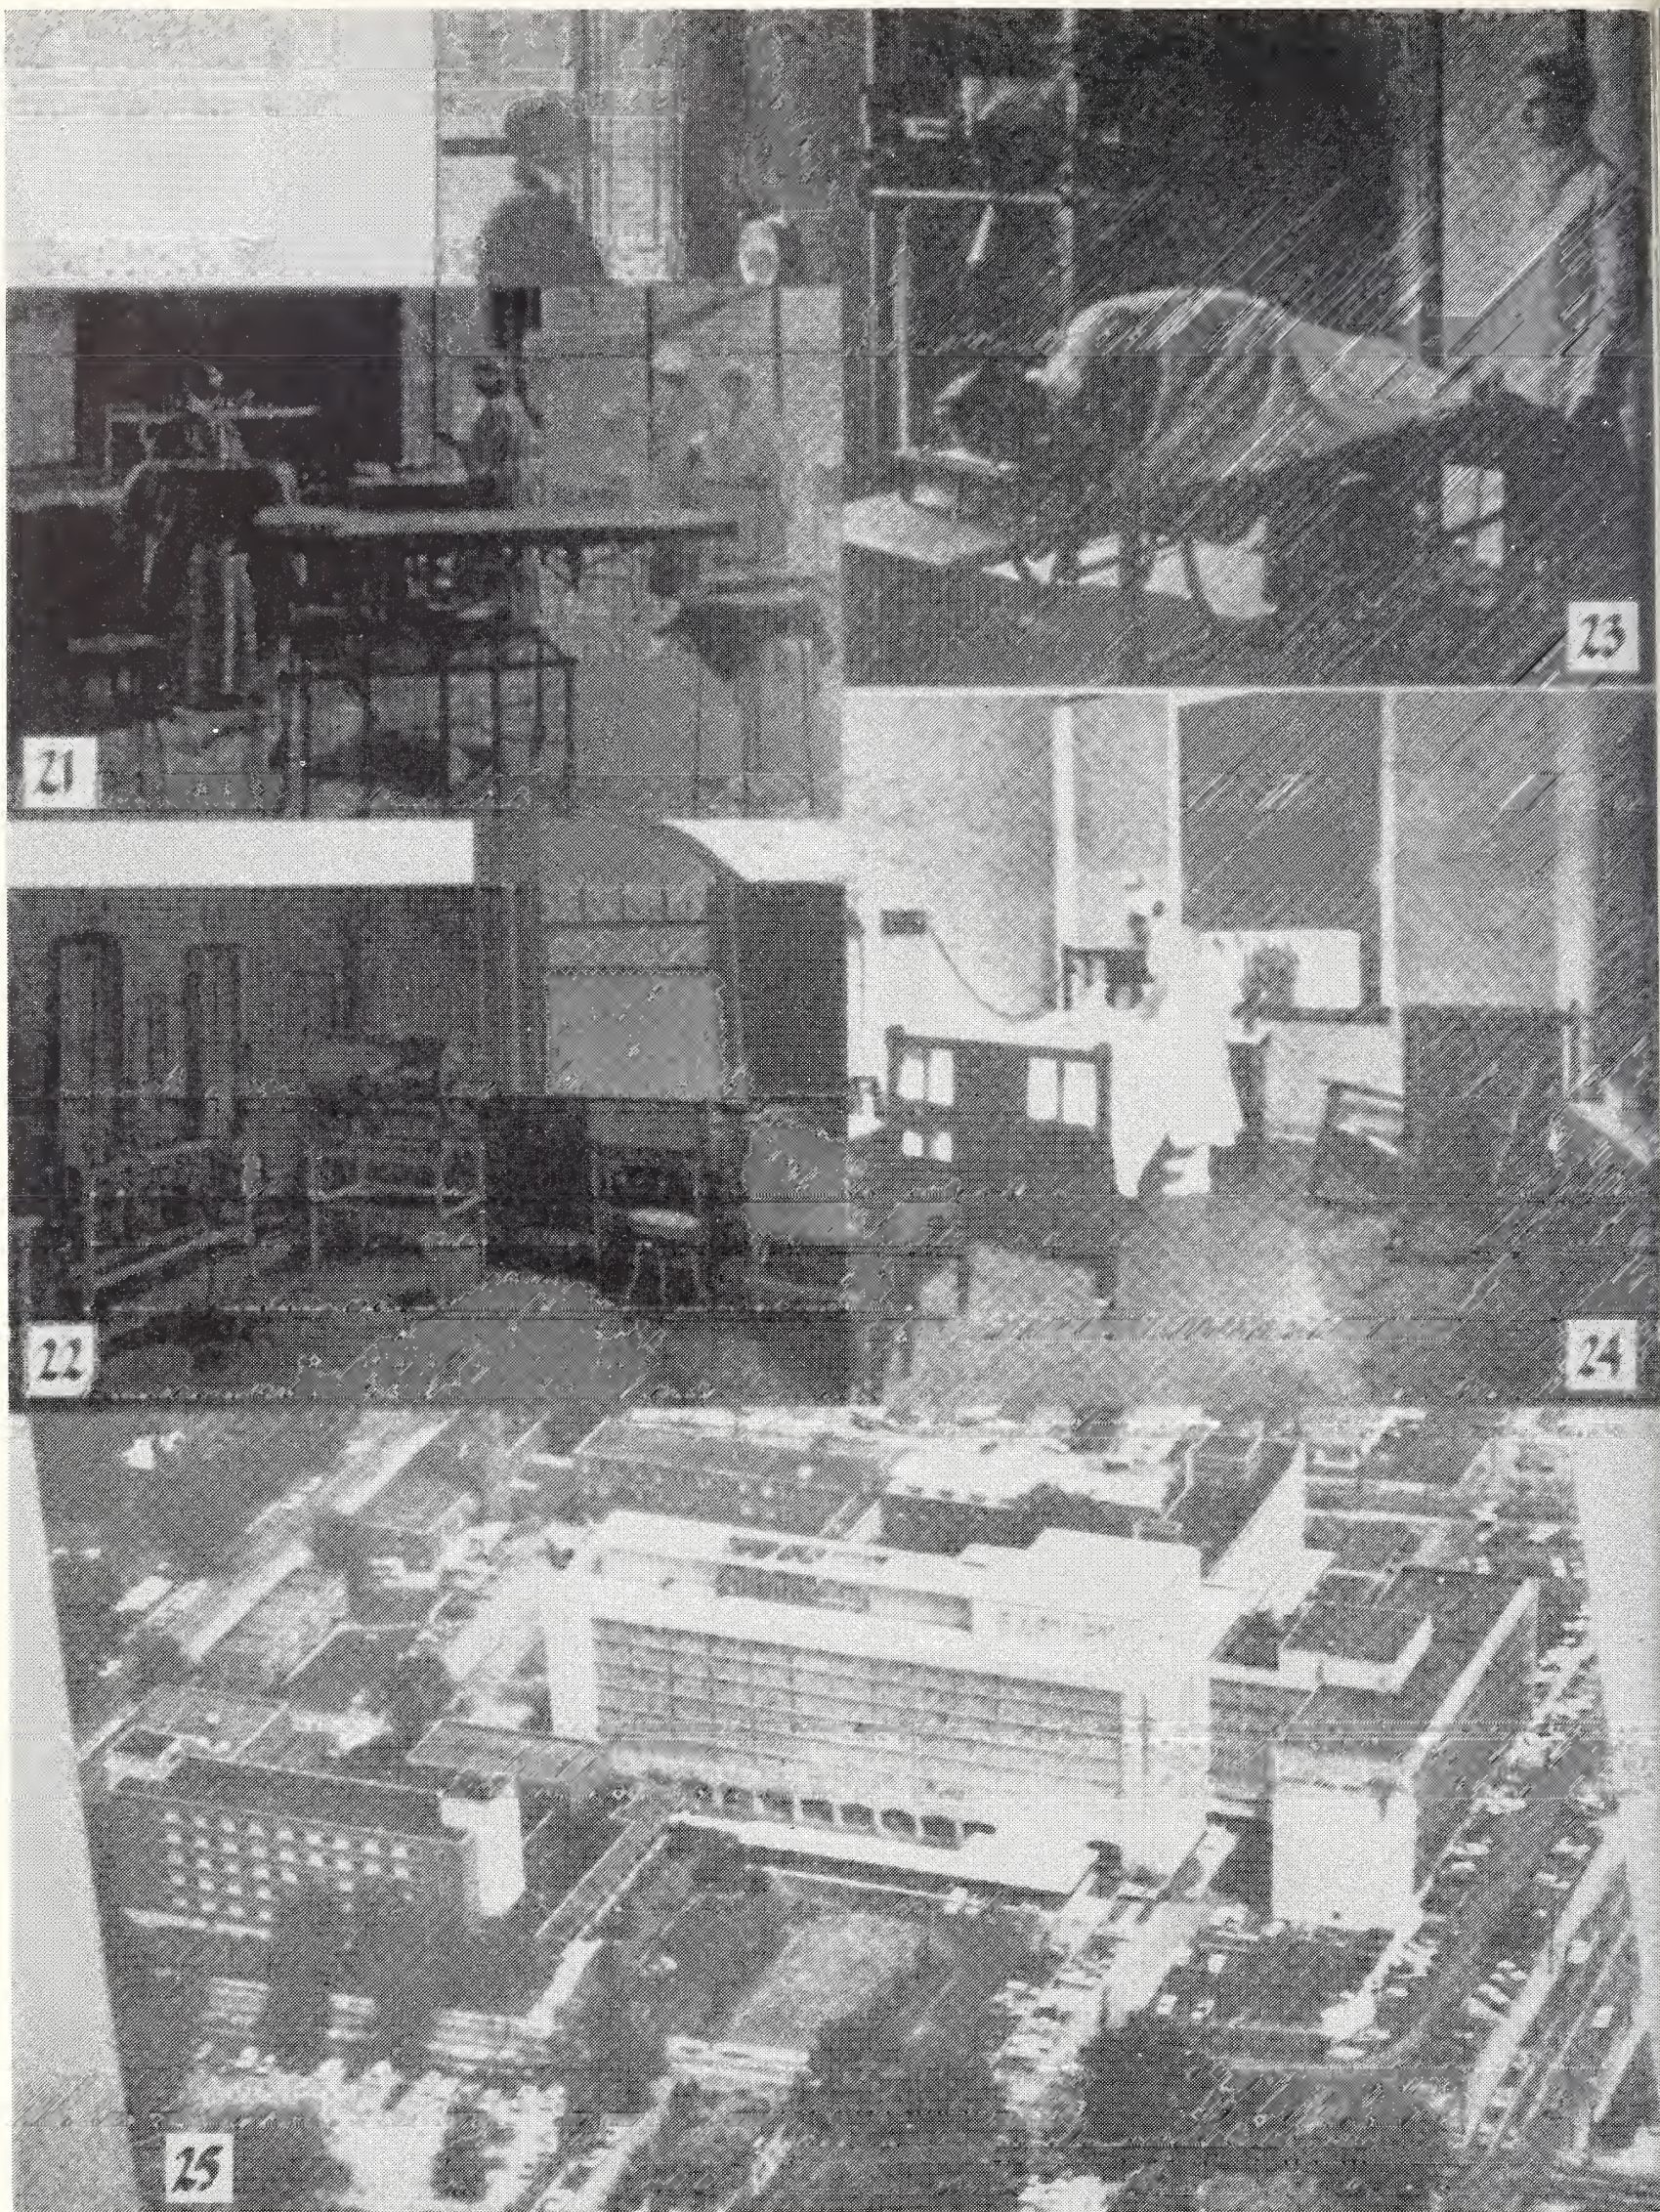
Operating Room, Protestant Hospital in East Wing, 1924; FIG. 22, The Sterilizing Equipment in the New East Wing, Protestant Hospital, 1924; FIG. 23, Latest in X-ray equipment installed in Protestant Hospital, 1924; FIG. 24, Patient's Room, Protestant Hospital, 1924; FIG. 25, Baptist Hospital, 1973.
